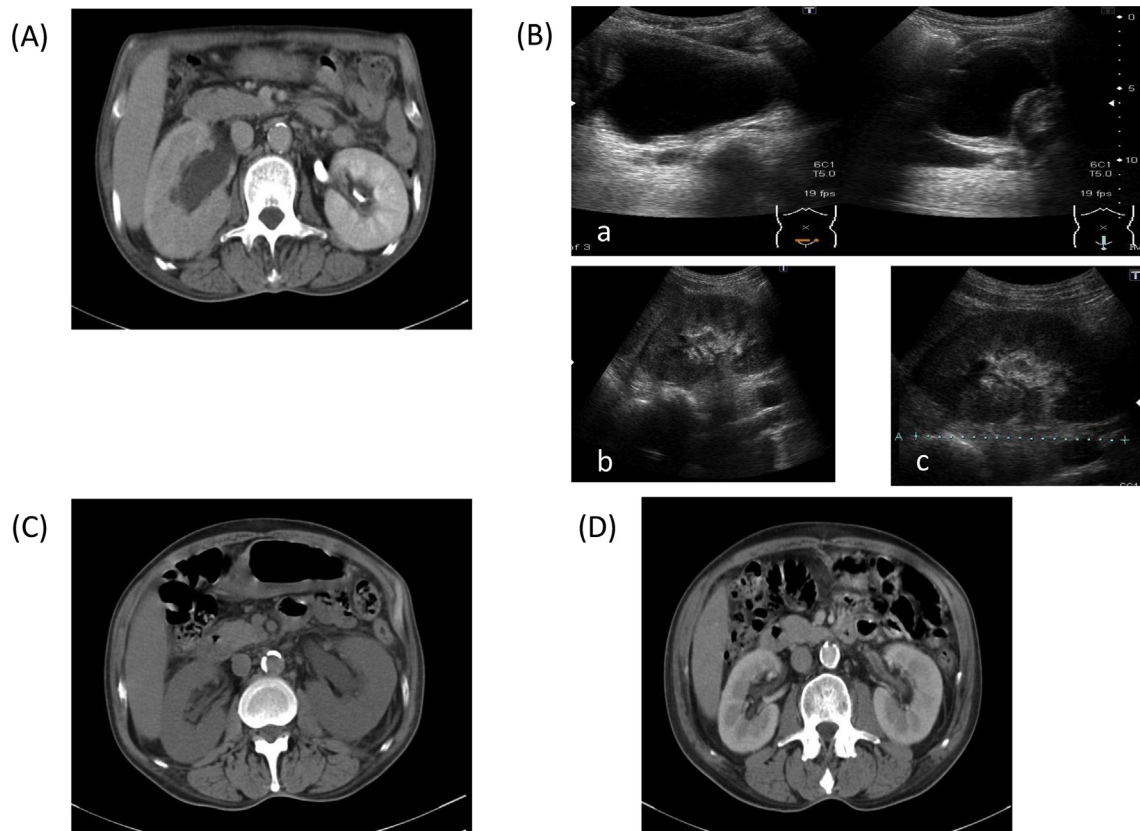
(A) Right hydronephrosis was detected on computed tomography before the antifungal treatment for pyelonephritis. (B) On admission, ultrasonic echography showed bladder wall thickening (a) without hydronephrosis (b, c). (C) Left hydronephrosis was detected on computed tomography during the treatment of oral voriconazole. (D) Left hydronephrosis improved rapidly by insertion of single-J stent and oral fluconazole treatment.
